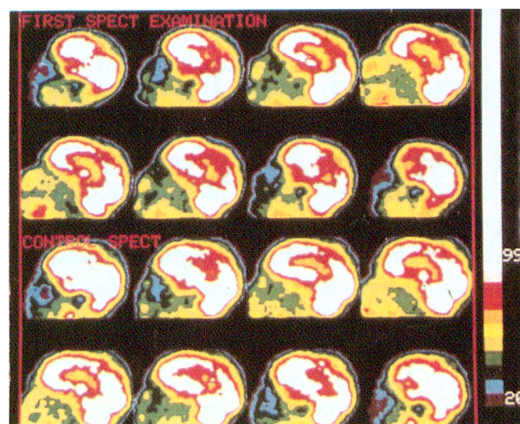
First two rows: ^{99m}Tc -HMPAO SPECT of the brain on Day 4, performed during exacerbation of the symptomatology. Sagittal slices are depicted progressing from right to left, with the nose oriented towards the left side of the picture. This SPECT examination shows a bifrontoparietal defect, larger on the right. Last two rows: control ^{99m}Tc -HMPAO SPECT of the brain on Day 19 after disappearance of echolalia and palilalia. The bifrontoparietal defect is now small when compared with the first examination.
